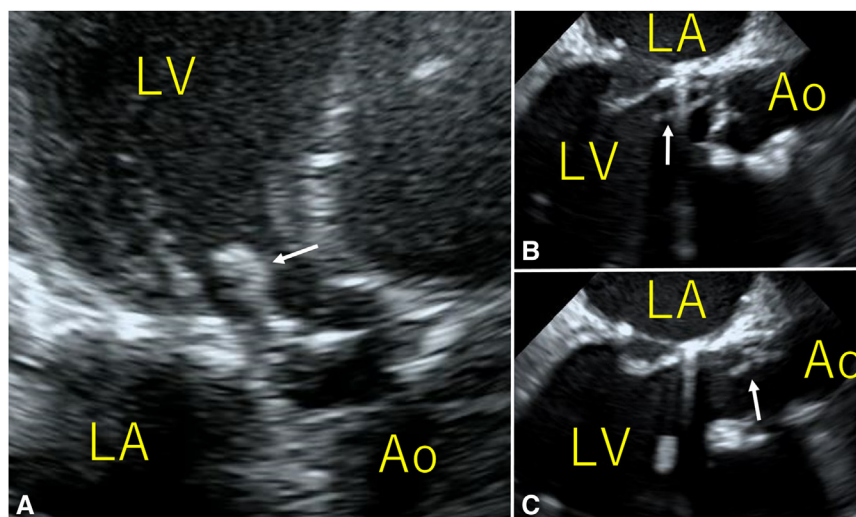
A, Transthoracic echocardiography and transesophageal echocardiography at (B) at diastolic and (C) systolic phase showing the mobile mass (21 × 12 mm) (white arrow) near the aortic valve, swinging back and forth between the ascending aorta and the left ventricle. LV, Left ventricle; LA, left atrium; Ao, aorta.
